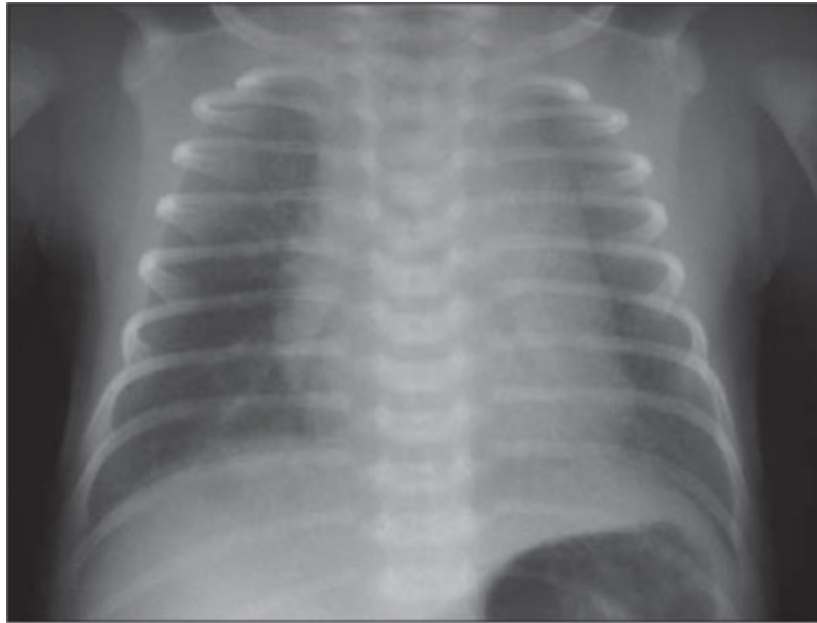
Physiologic chest radiograph of a two-hour-old infant [21].
